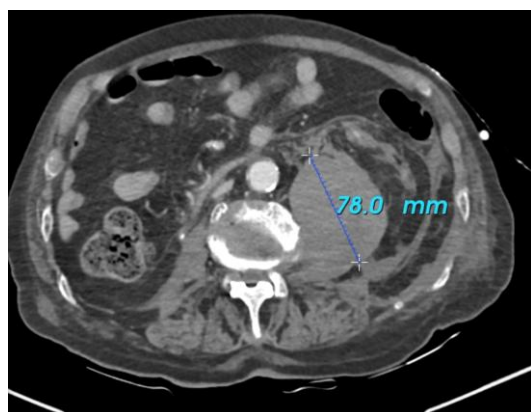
A coronal CT scan of the abdomen showing the left psoas muscle enlarged compared to its symmetry, measuring 78x60 mm at its widest point in the axial plane
